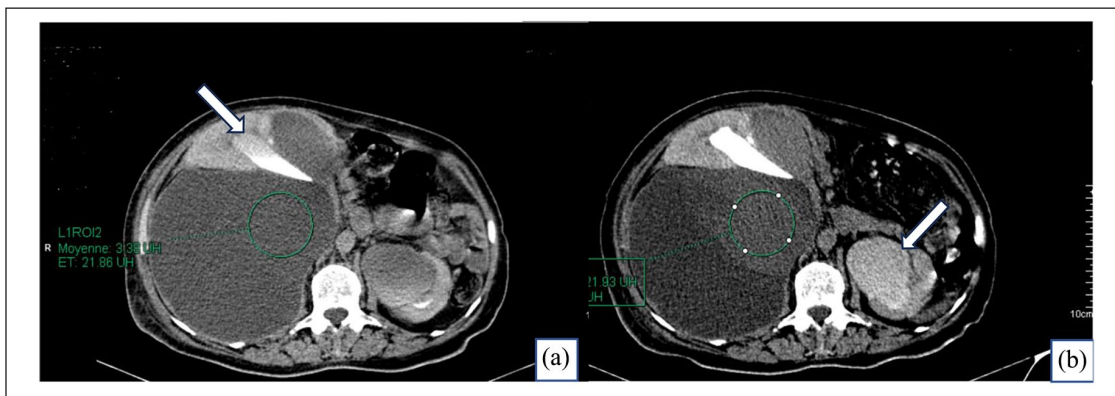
Axial abdominal computed tomography-scan in delayed phase performed at 15 min and 2h: Bilateral pelvic dilation more pronounced on the left (arrows). At 15 min (a), the measured density was 3.3 Hounsfield Units (HU), increasing 2h later to 22 HU, proof of a slow and progressive filling of the fluid mass by the contrast agent (b).
